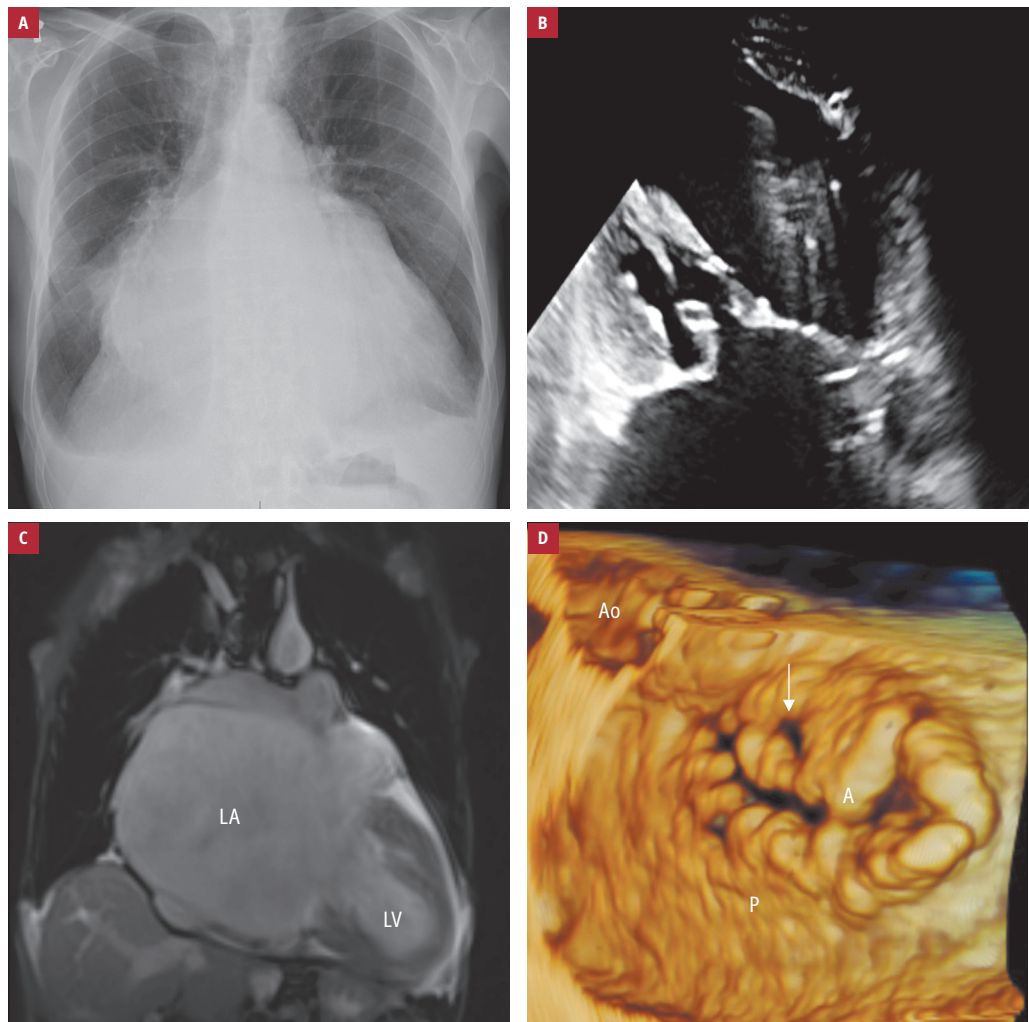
Imaging of a giant left atrium: A – chest X-ray; B – transthoracic echocardiography; C – cardiac magnetic resonance imaging; D – 3-dimensional transesophageal echocardiography showing the perforation (arrow)
